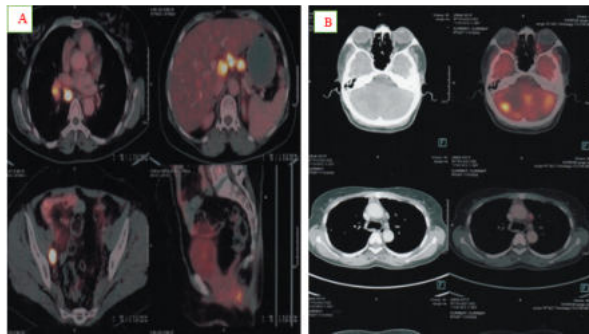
Whole body 18-FDG PET CT scan showing mass both in ovary and in brain for case (A) and (B)
